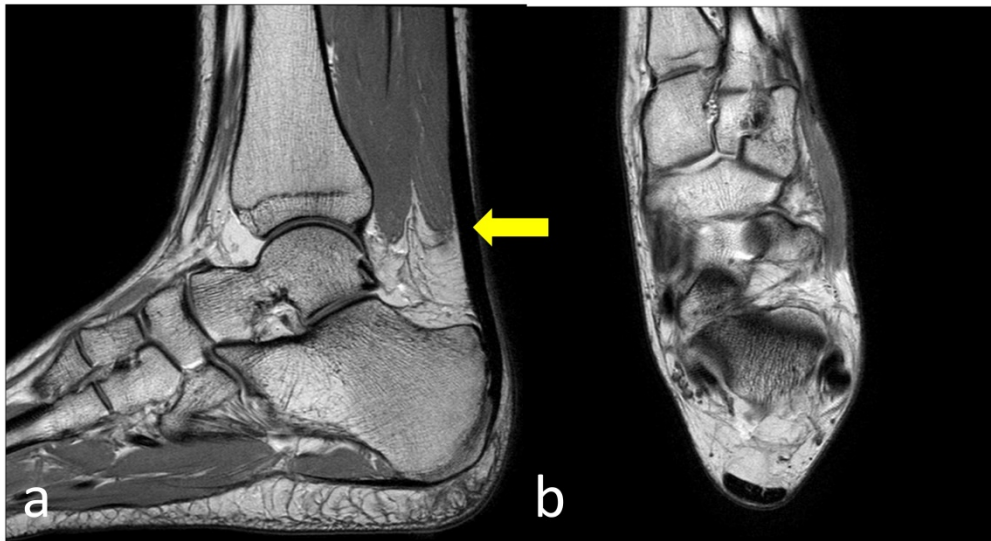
Magnetic Resonance (MR) imaging of the normal Achilles tendon. (a) Sagittal and (b) Axial Proton-density sequence MR image showing a normal Achilles tendon (arrow) with uniform thickness and predominantly low signal intensity
